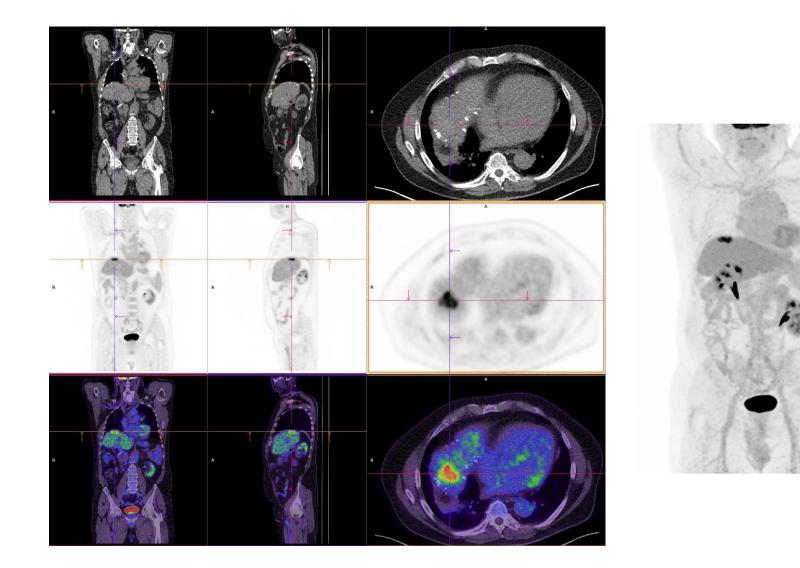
Sixty-eight-year-old man with a previous history of rectal carcinoma. A single liver metastasis is demonstrated by contrast enhanced CT and FDG-PET (left: transverse slice; right: coronal slice). Note the high quality of the attenuation corrected images.
